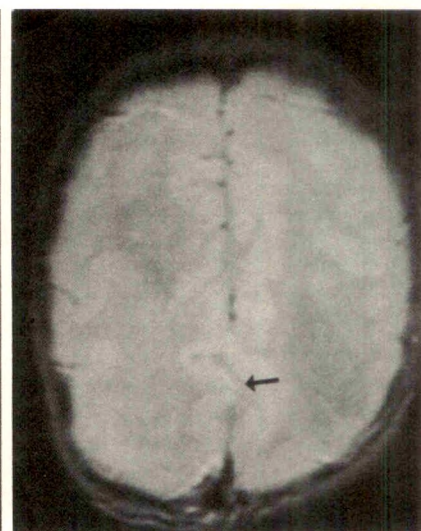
Coronal SE 2500/35 MR image of patient with severe hydrocephalus resulting from aqueductal stenosis. Septum is thin inferiorly (arrowheads) and absent centrally (arrow). A wide range of thinning and partial absence of septum was seen in patients with aqueductal stenosis and Chiari II malformation. Pressure necrosis of septum, resulting from longstanding hydrocephalus, may be the cause of these septal anomalies.
